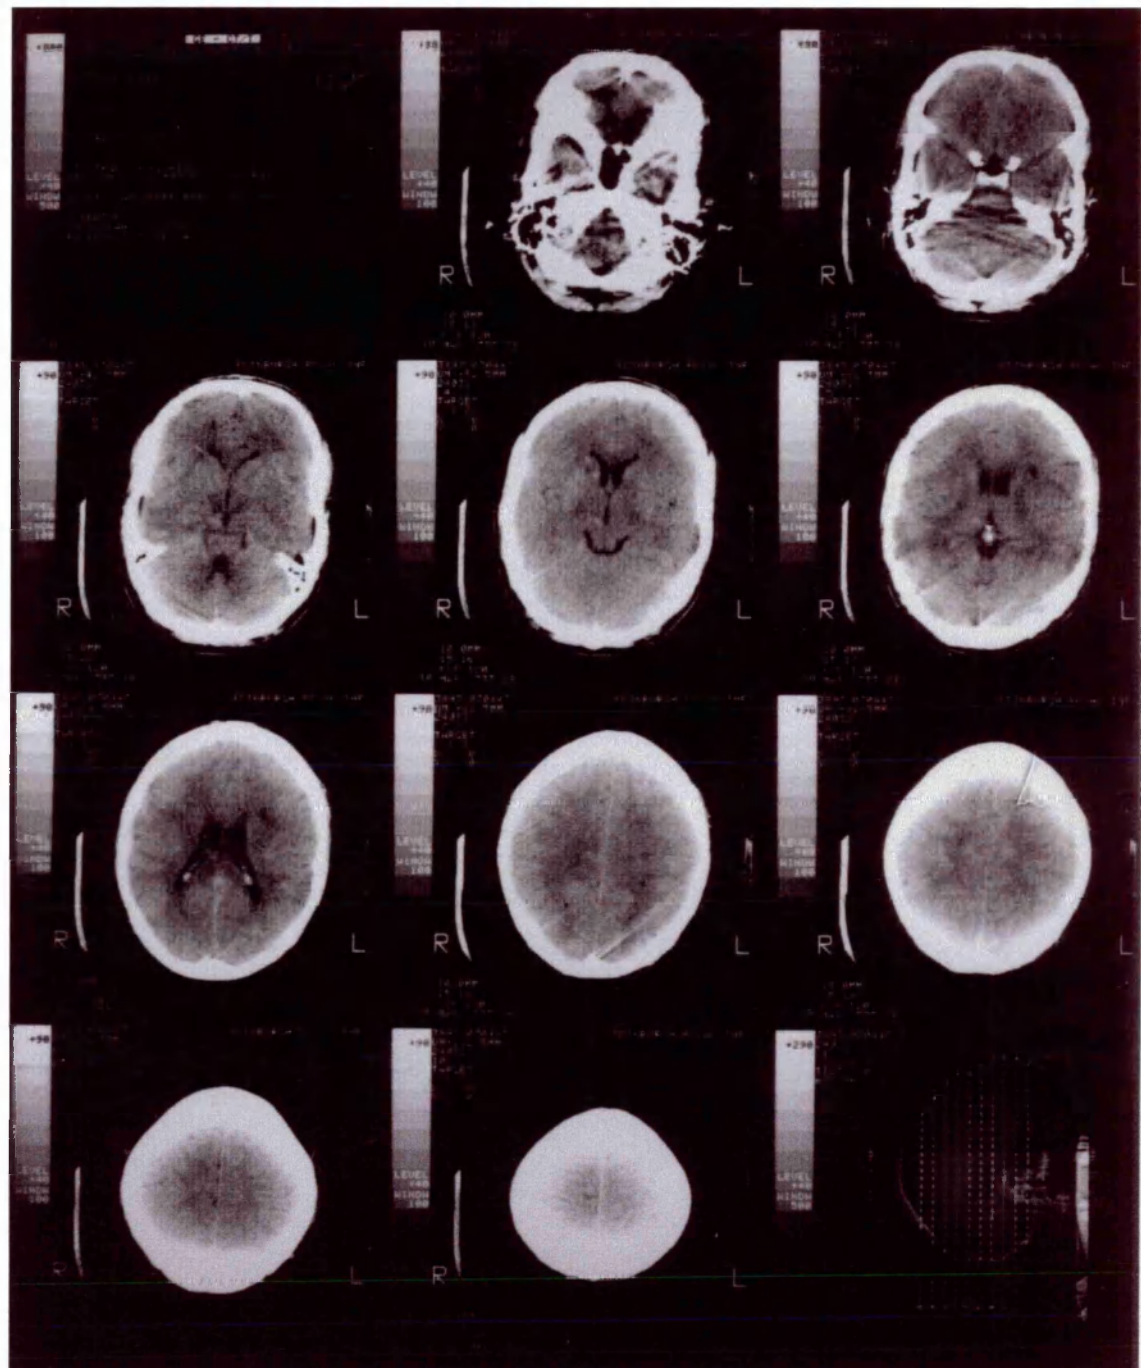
CT scan for CR.
